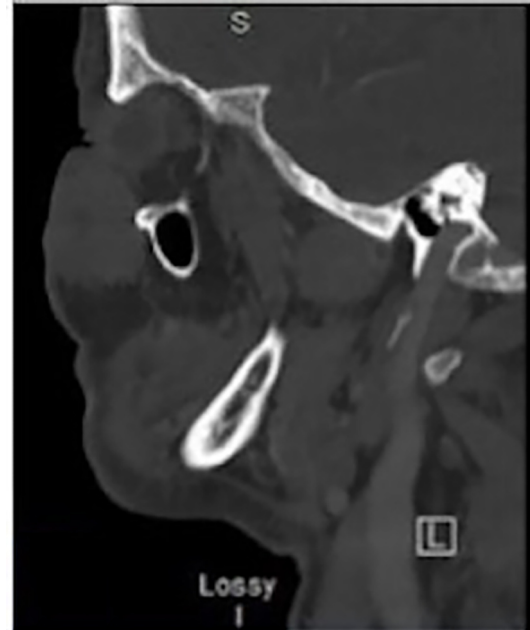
Computed tomography (CT) imaging of the infraorbital mass. Contrast-enhanced CT was obtained to aid with diagnosis, revealing a 4.4×2.2×3.2 cm mass. The mass is displayed in sagittal cross-sectional view.
